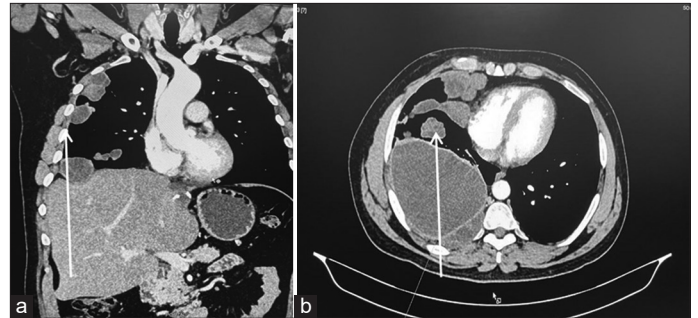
Computed tomography scan showing multiple hydatid cyst along the pleural border along with herniated hepatic cyst
